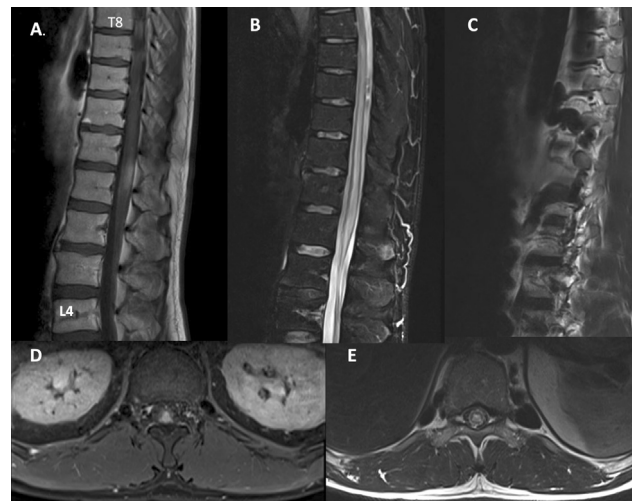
Magnetic resonance imaging—(A) T1-weighted postcontrast slice showing a contrast enhancing region at the T12-L1 level and (D) representative axial slice through L1 level showing enlarged cord and enhancing region located in dorsal part of cord. (B) T2 fat-saturated sagittal image demonstrating central cord myelopathy from T8 to L2. (C) Sagittal T2 image demonstrating flow voids of the dilated paraspinal varices (E) Axial through T11 demonstrating flow voids of the dilated paraspinal varices, and central cord myelopathy.
